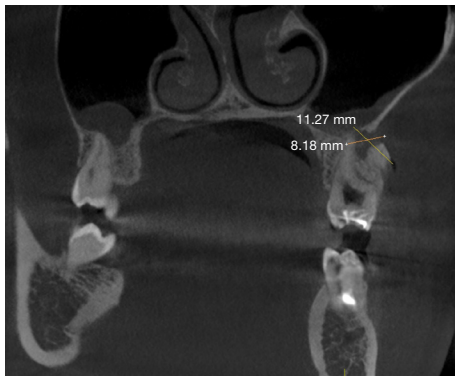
Tooth 1.6 on CT, coronal plane view, where a complete destruction of vestibular alveolar cortical lamina and a sequestered bone fragment are observed.
